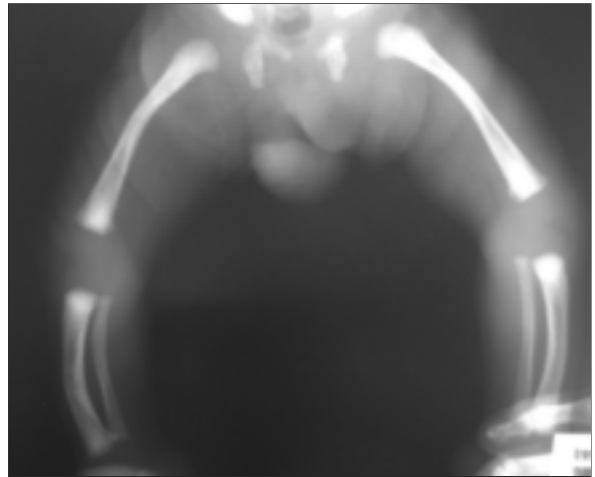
Radiograph of lower extremities showing bowed femora and tibiae.
